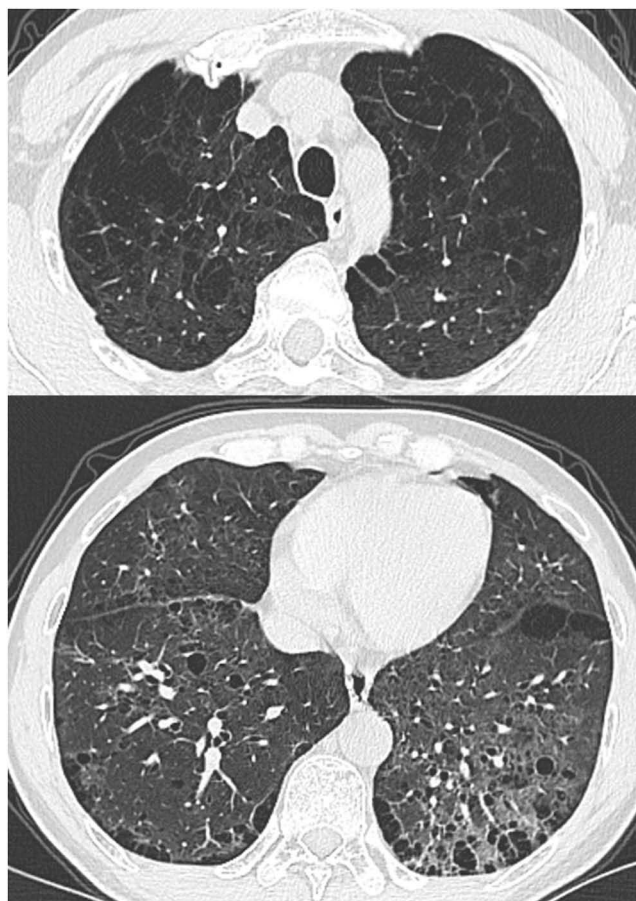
HRCT findings of Case 1 (2023-12-29). Top image: Significant decreased translucency in both upper lungs, showing emphysema changes. Bottom image: Diffuse thickening of the interlobular septa in both lower lungs, with strip-like, nodular, ground-glass, and reticular high-density shadows. Local honeycomb changes and traction bronchiectasis are visible.
